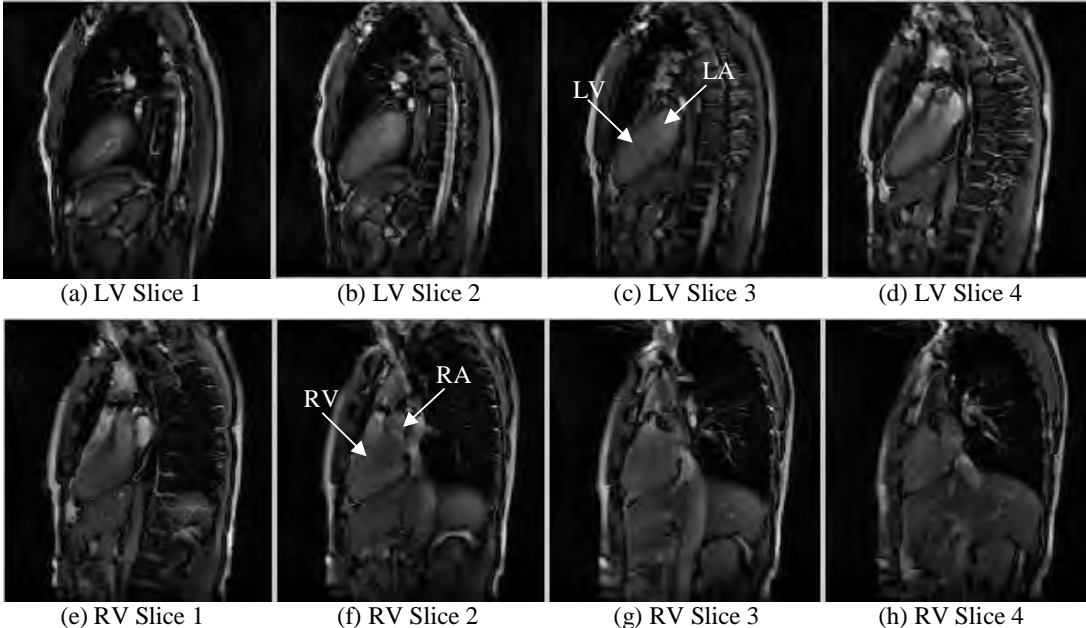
Examples of Cardiac MRI in Two Chamber View. (a) to (d) are per slice view depicting the left ventricle and left atrium. (e) to (h) are per slice view depicting the right ventricle and right atrium.
